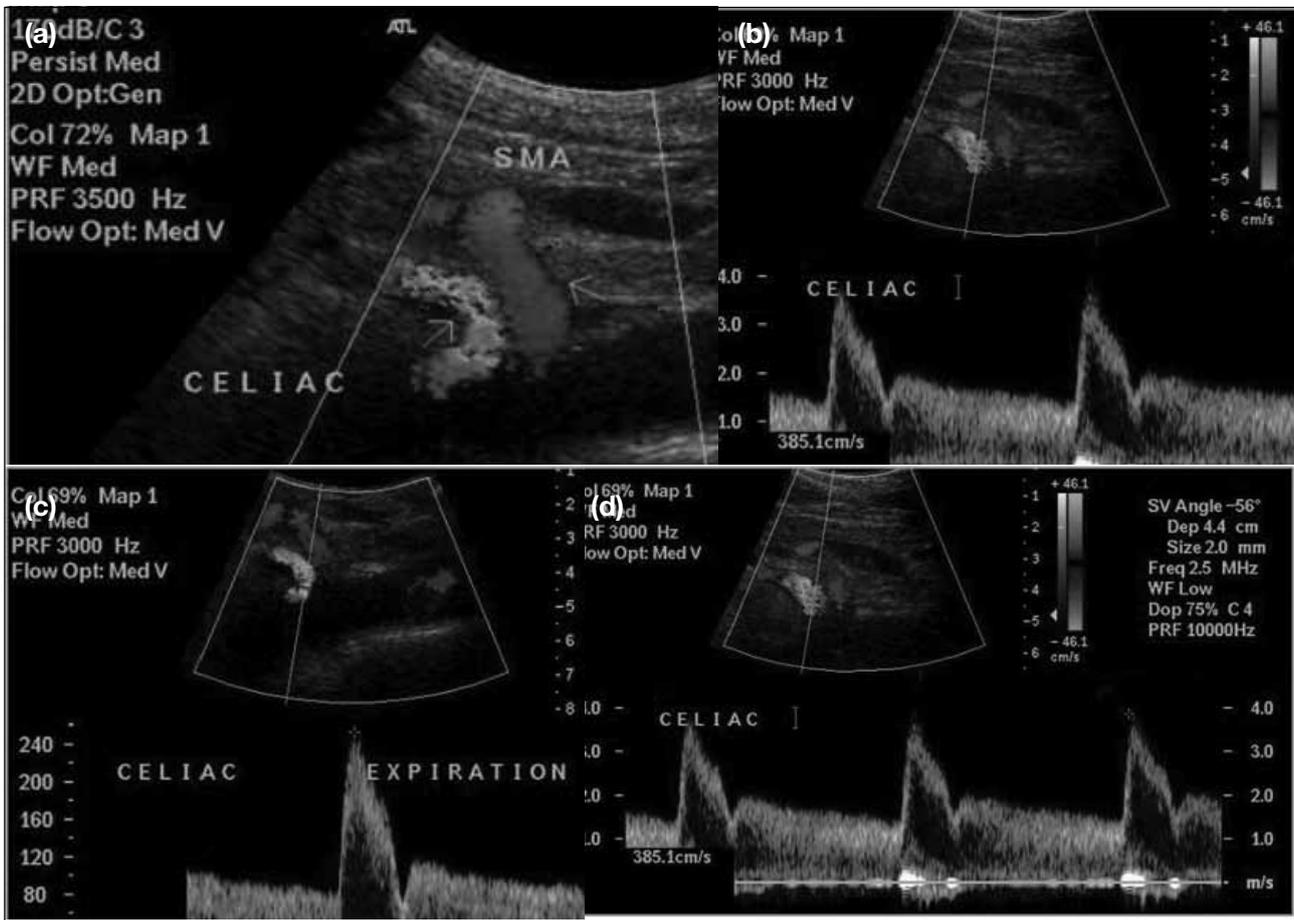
Patient B: (a) Ultrasonographic Doppler showing aliasing of the colour Doppler at the proximal celiac artery. (b) The peak systolic velocity (PSV) in the celiac artery is above 300 cm/s. (c) During expiration, the PSV of the celiac artery is above 200 cm/s. (d) During inspiration, the PSV in the celiac artery is normal (<200 cm/s).
